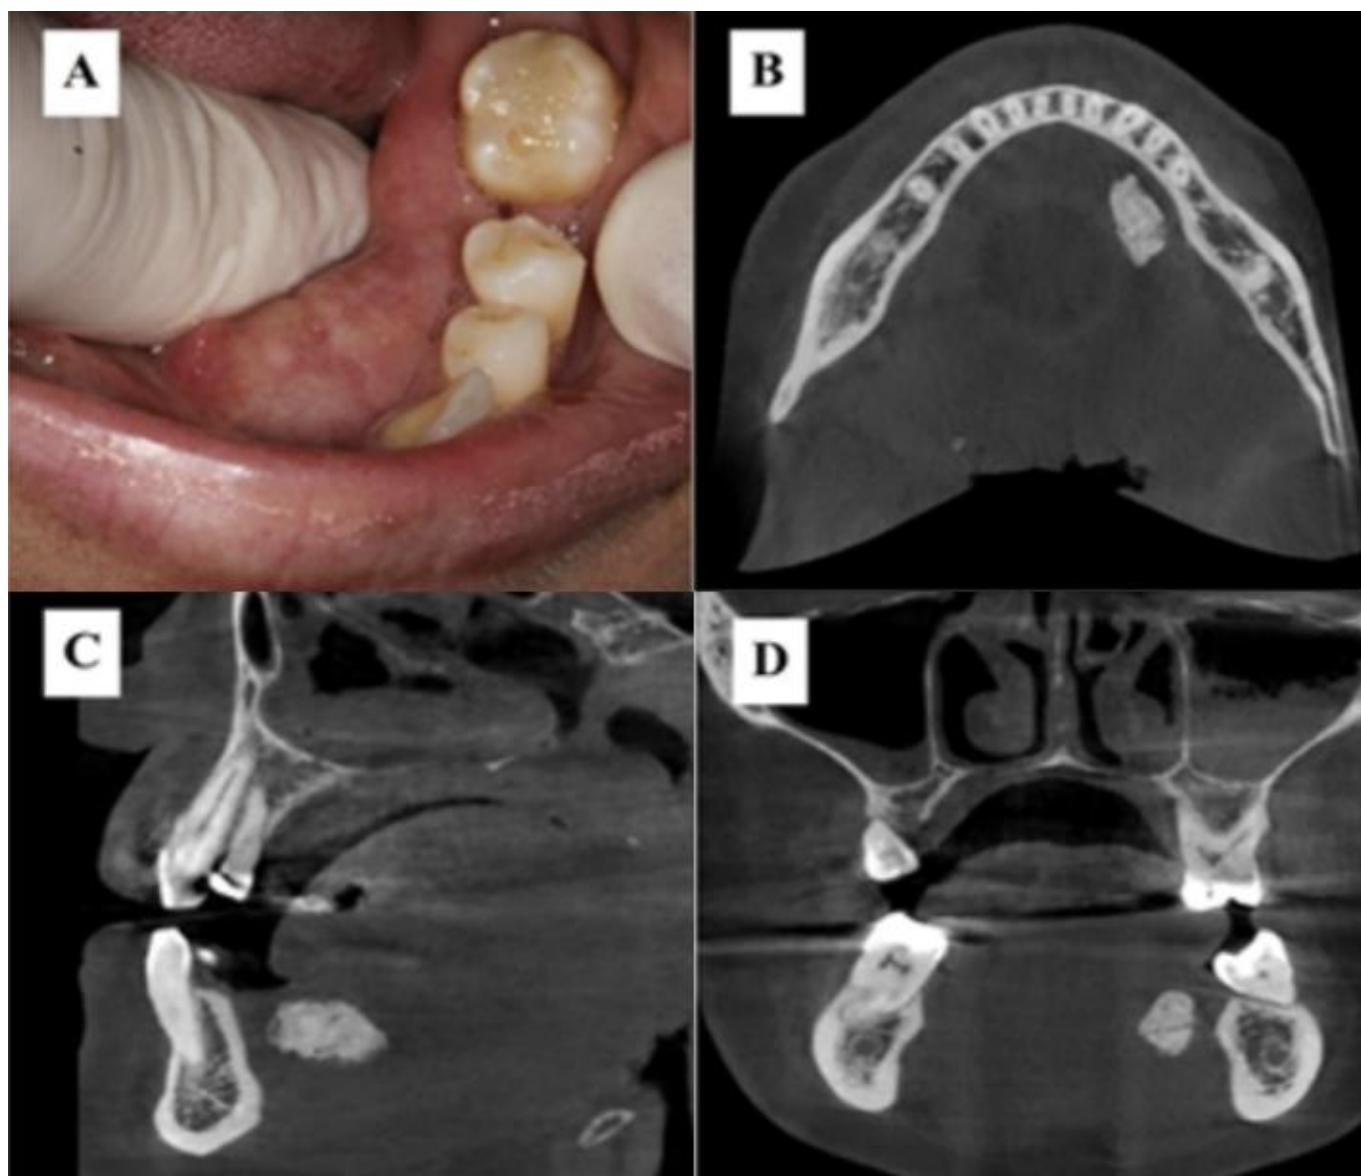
Clinical examination and Cone-beam computed tomography (CBCT) images showing a radiopaque mass compatible with a sialolith in different planes: (A) Preoperative intraoral aspect showing sublingual nodule. Cone-beam computed tomography: (B) axial view. (C) Sagittal view. (D) Coronal view.
